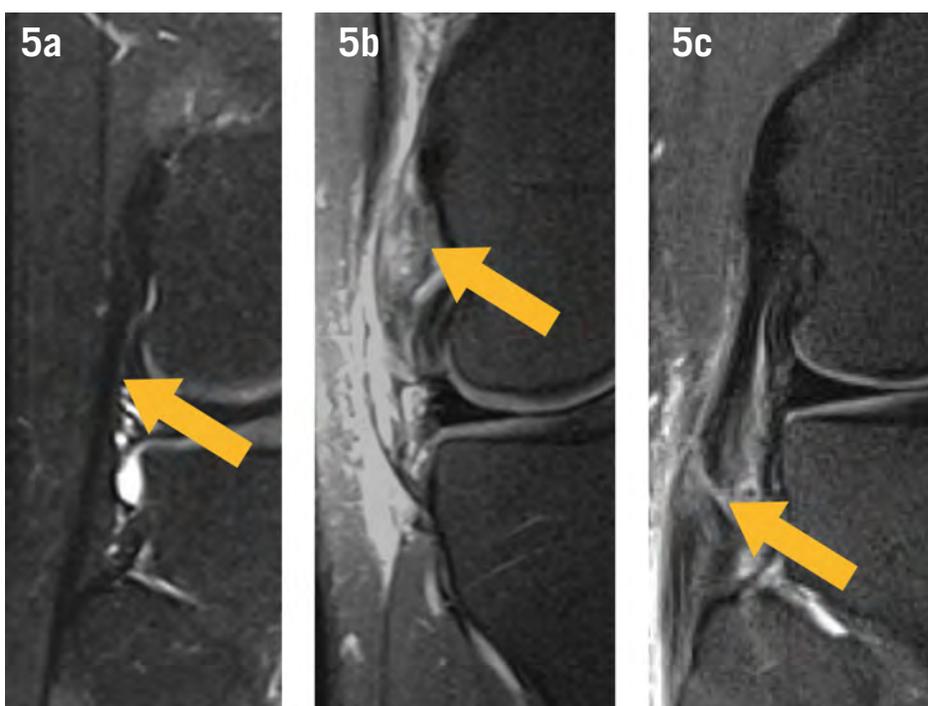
Magnetic resonance imaging of the lateral collateral ligament. Three cropped coronal T2 weighted images of the lateral collateral ligament of different patients depicting a normal (a), partially torn (b) and completely torn (c) ligaments. The normal ligament shows homogeneous low signal and regular morphology. The partially torn ligament shows increased signal and irregularity of the fibers, but no complete discontinuity. The completely torn ligament shows a full-thickness tear, pointed by the arrow.
